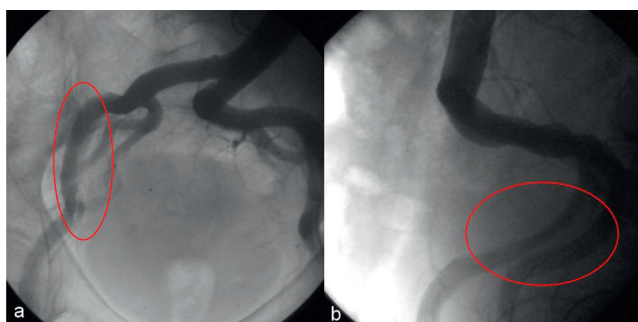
Invasive angiography. (a) Anterior-posterior projection of an aorto-iliac angiogram with tortuous arteries and dissection caused by the wire during preprocedural invasive evaluation. No flow compromise was observed and no treatment was necessary. The dissection was no longer detectable by CT after two weeks and the patient was successfully treated by transfemoral approach from the right common femoral artery later on. Suitable vessel diameters and low degree of calcification made the femoral access possible despite tortuosity. (b) Lateral (LAO 80°) projection of the aorto-iliac angiogram with the dissection already shown in panel a. The dissected segment is longer than expected from the anterior-posterior projection.
